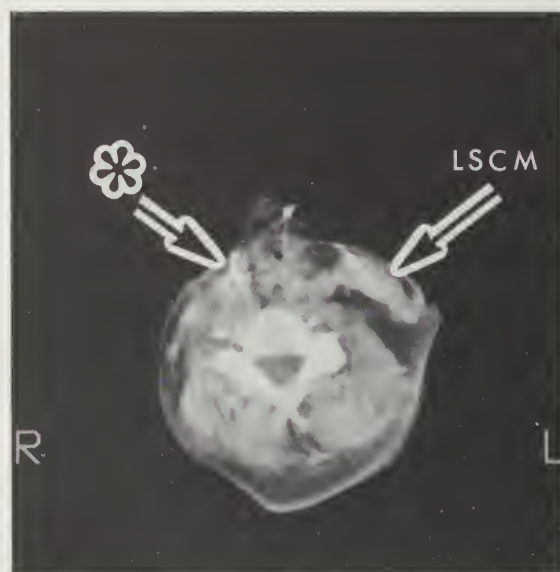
Postoperative CT with contrast at approximately the same level as the previous scan, no evidence of residual tumor, absence of hyoid, larynx, and right sternocleidomastoid muscle. Note star artifact(*) from metallic surgical clips (LSCM — left sternocleidomastoid muscle).
